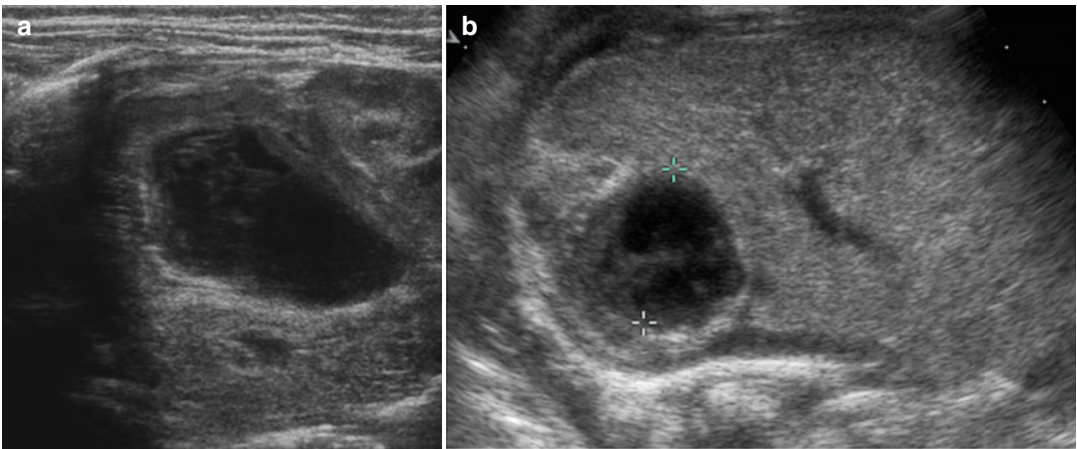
(a) Ultrasound scan with linear probe and with (b) convex probe on an infant with an adrenal hemorrhage shows the best definition of the linear probe compared to the wider panoramic of the convex probe
